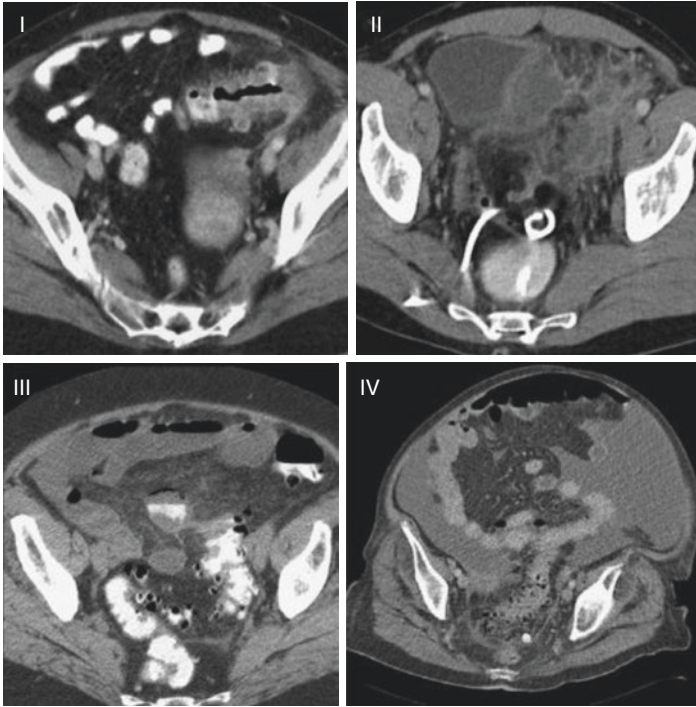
CT scans demonstrating representative images for Hinchey classes I-IV complicated diverticulitis. (*Courtesy of NIH*)
